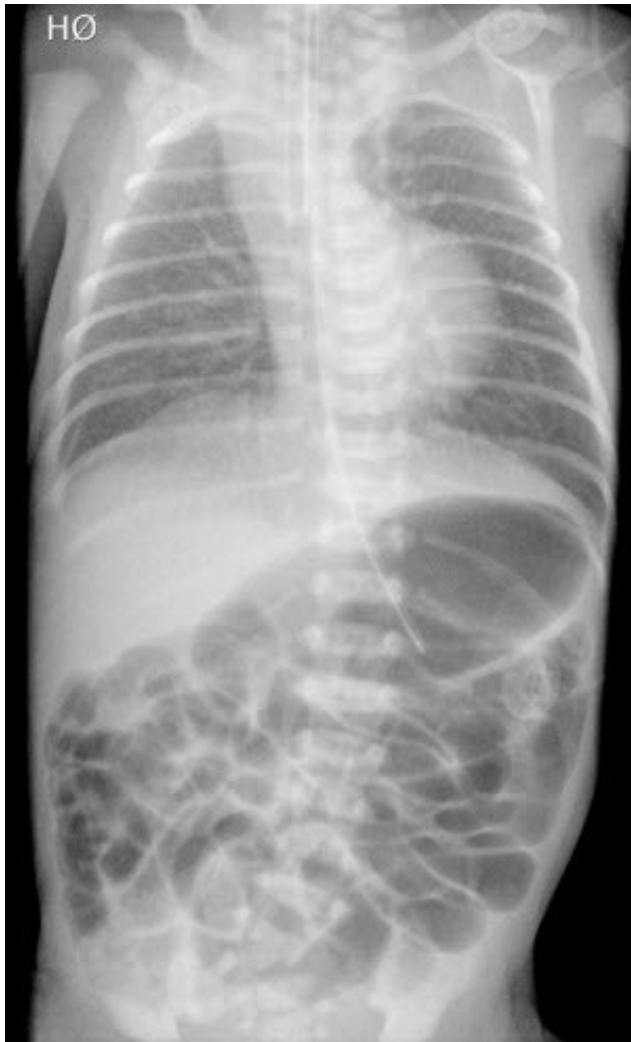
Tracheal agenesis. Boy on his first day of life. Conventional x-ray front of the chest. He is intubated with the tracheal tube in the level of fourth thoracic vertebra. The lungs have reduced air content.
